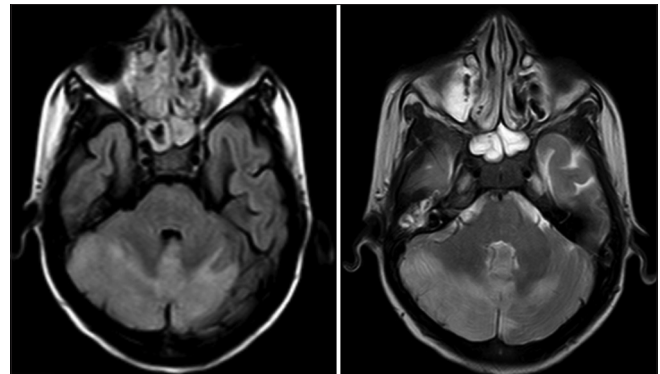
Acute disseminating encephalomyelitis: Diffuse ill-defined abnormal signal intensities are seen predominantly involving the cortices of both cerebellar hemispheres (R>L) and cerebellar vermis, appearing homogeneously hyperintense on T2 and fluid attenuated inversion recovery, hypointense on T1-weighted. There is minimal mass effect seen in the form of effacement of the involved sulci
